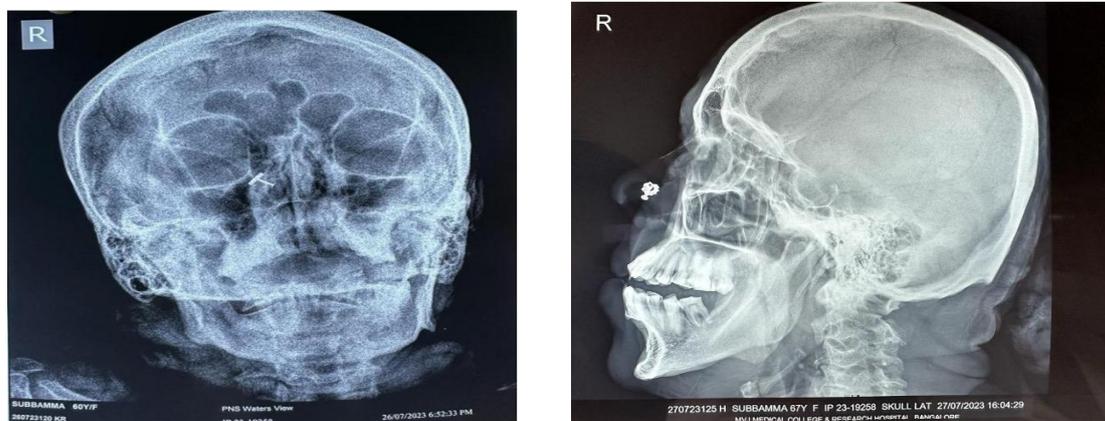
X-Ray of PNS showing enlarged frontal sinus and X-Ray of skull lateral view showing calvarial thickening and mandibular prognathism.
